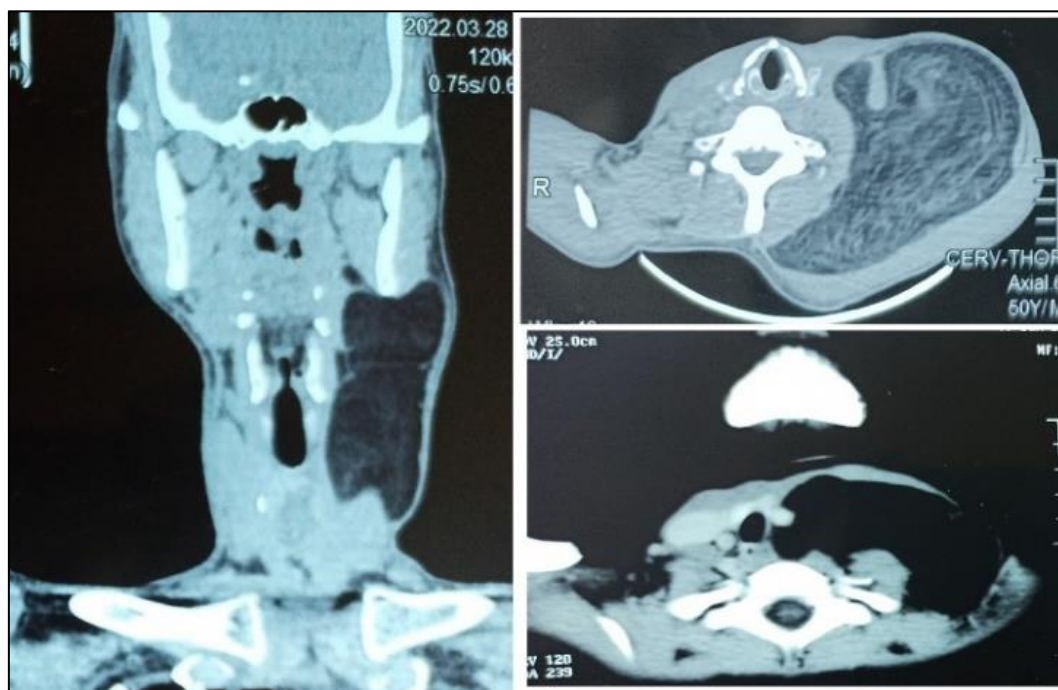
CT scan showing well-demarcated, hypodense, non-enhancing lesions in the neck consistent with a cervical lipoma.
